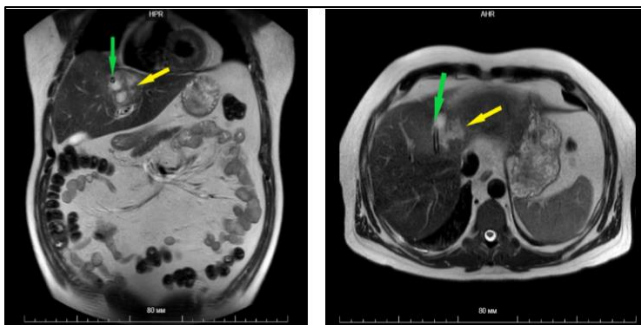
Abdominal MRI (control on the 14th day after surgery). The abscess has significantly decreased in size (yellow arrow), there is a Foley catheter drainage tube in its cavity (green arrow).
